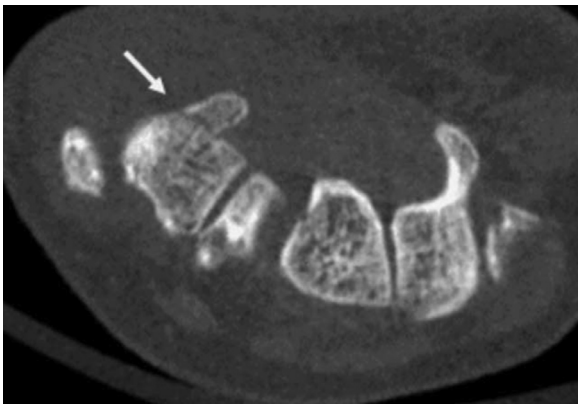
48 year old male who fell from a scooter. CBCT demonstrated a radiographically occult trapezium tubercle fracture (arrow).
